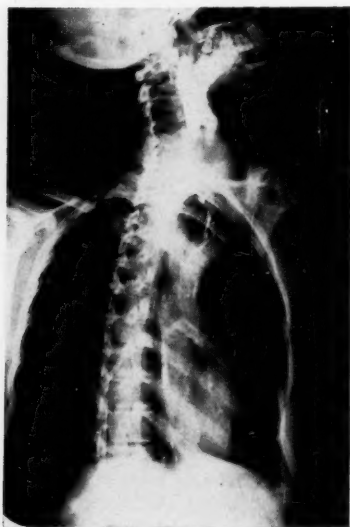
Case 6.—Benign stricture of the esophagus. Resection of the esophagus with primary high cervical esophagogastric anastomosis. Postoperative fistula and stricture. Roentgen study reveals high level of anastomosis and presence of obstruction.
